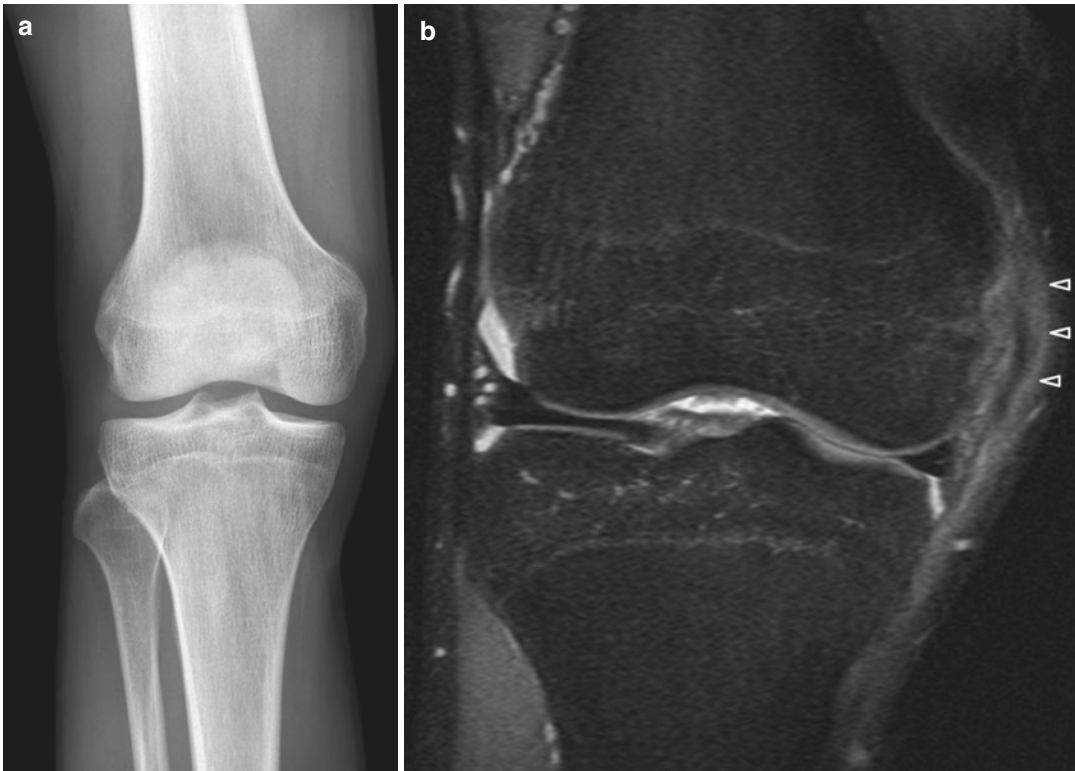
A 25-year-old man who presented with right knee pain after sustaining an injury from a tackle during a football match. (a) Frontal radiograph of the right knee shows no fracture or dislocation. (b) Coronal fat-suppressed PD-W MR image of the right knee shows a
